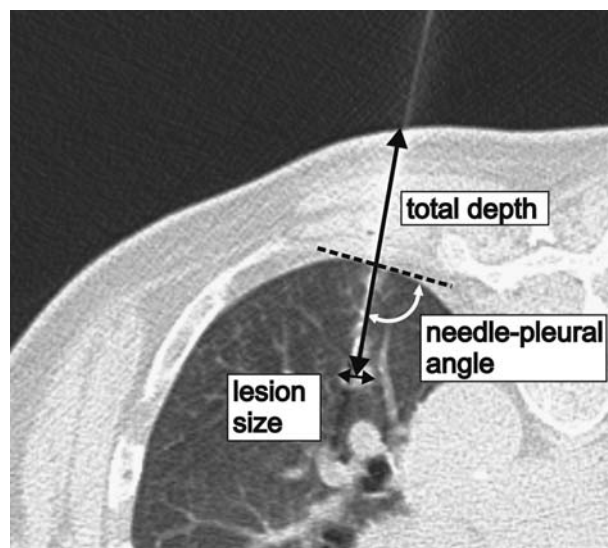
A representative CT scan showing the parameters that were recorded from the images.
